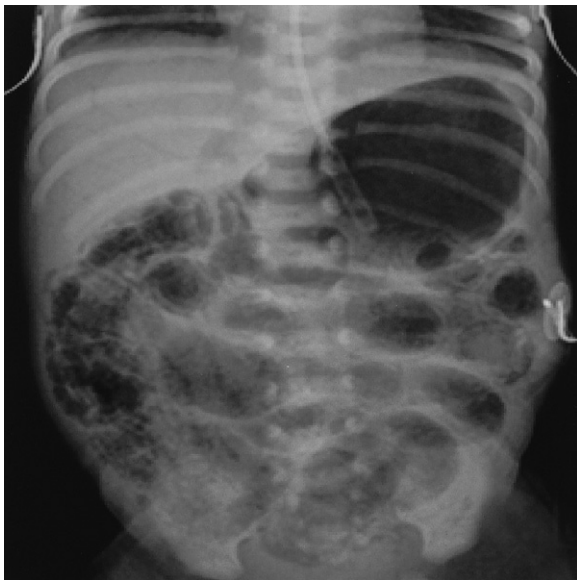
Plain abdominal radiograph demonstrating extensive pneumatosis intestinalis (cystic and linear) and an arborizing pattern of air over the liver shadow representing gas dispersed within the radicles of the portal venous system.
